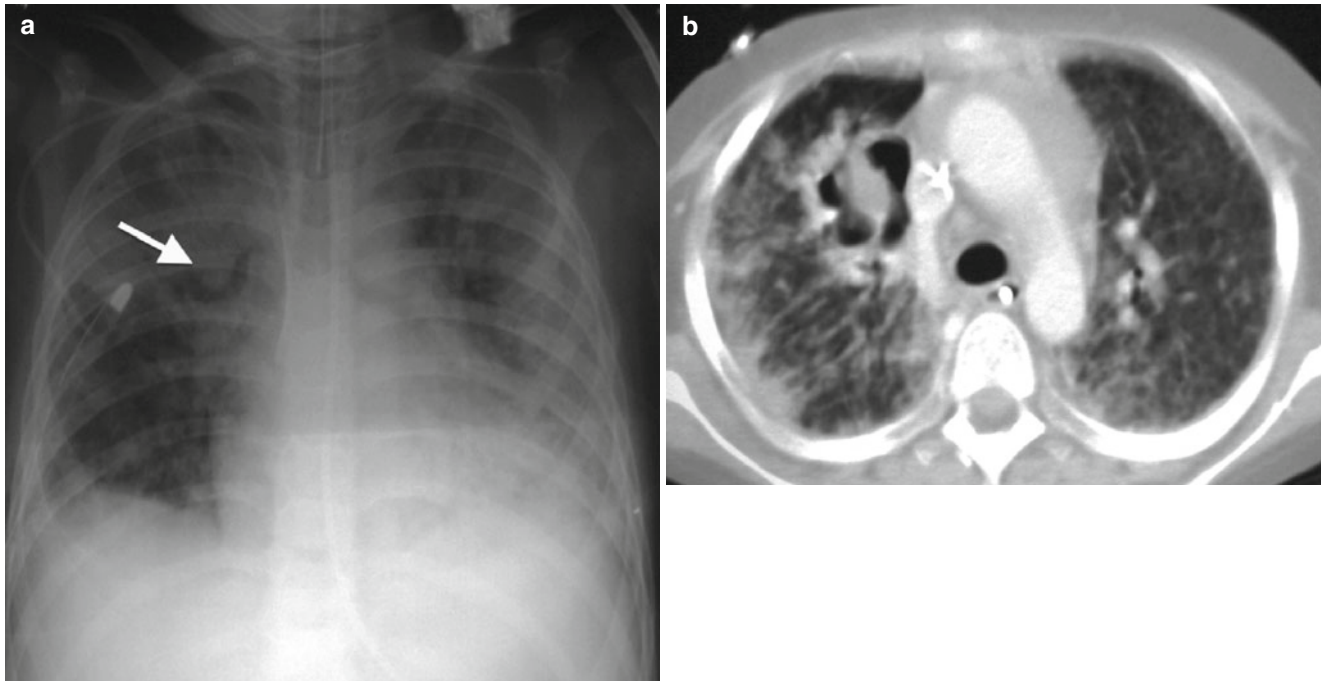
Aspergillosis in the immunocompromised. Chest radiograph of a 3-year-old boy status post bone marrow transplant for leukemia (a) showing diffuse interstitial and alveolar disease with suspected
